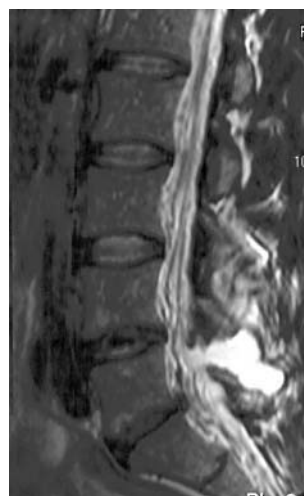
MRI of the lumbar spine (sagittal T2 sequence) showing pseudomeningocele at L5/S1 with extension from the dorsal dura to the paraspinal muscles.
